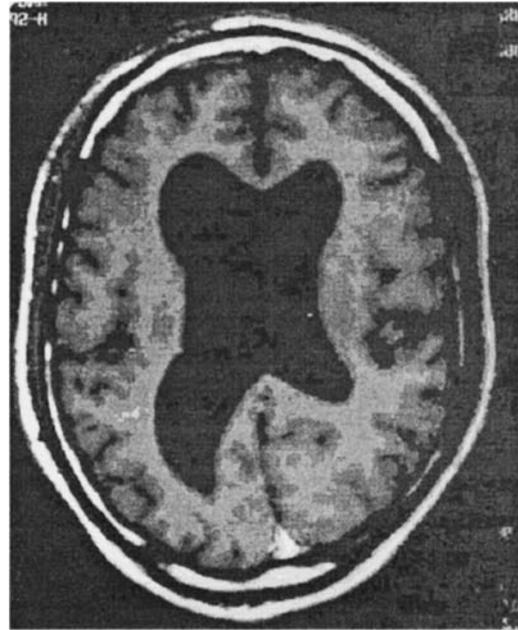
Transverse section (MRI scan) of the patient showing enlargement of both lateral ventricles, especially the left.
